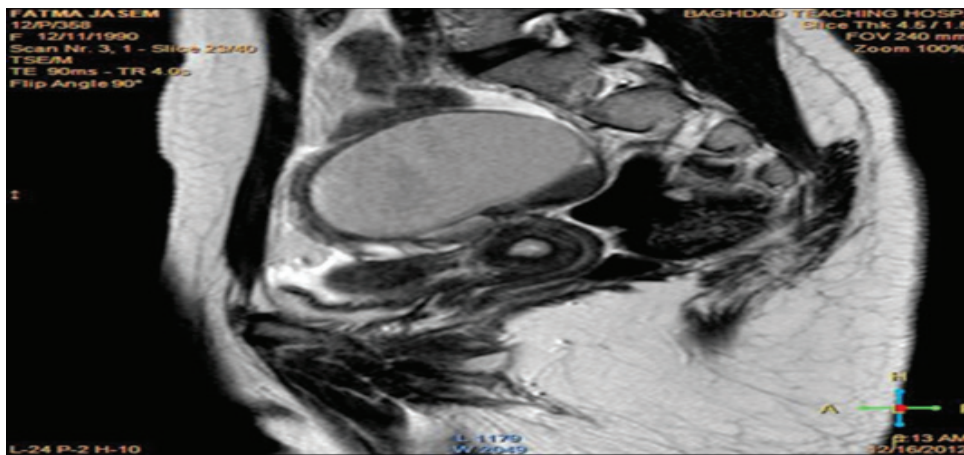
Sagittal T1-weighted image.
